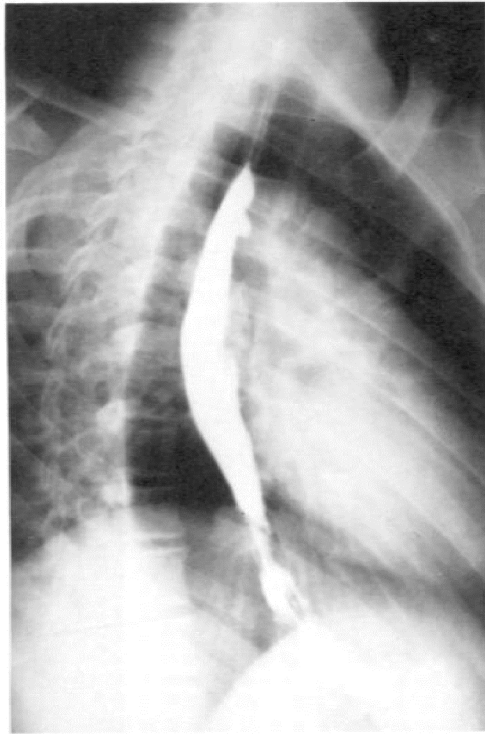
RAO single-contrast esophagus radiograph.
